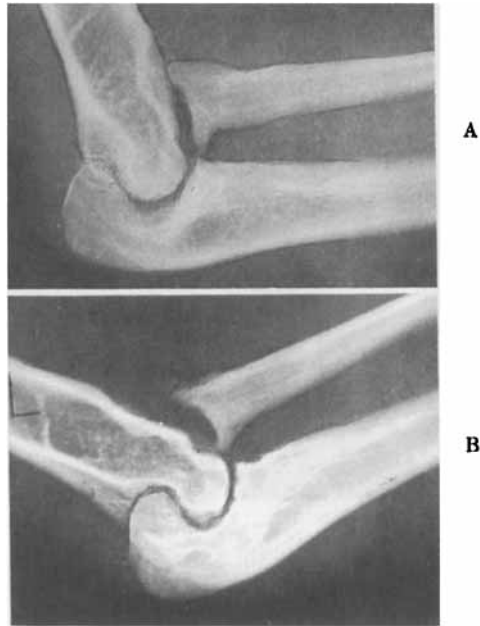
Roentgenogram of the left elbow, 13 years after operation (operated at the age of one year). Flexion, which is limited by the proximal end of the radius pushing against the humerus, could have been improved by another operation. Note change of the mutual size of the fore-arm bones towards normality.
